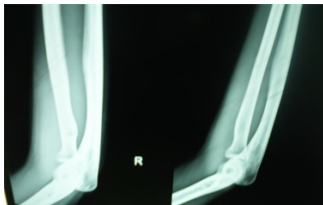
radiograph of forearm
